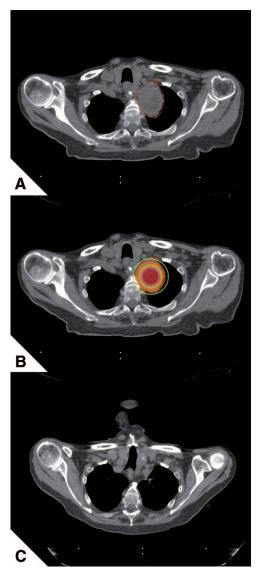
A 77-year-old man with squamous cell carcinoma of the left-sided superior sulcus. The patient suffered from chronic obstructive pulmonary disease, chronic renal insufficiency, and chronic cardiac insufficiency as coexisting morbidities and was medically not amenable to lung surgery. He rejected radiochemotherapy and was treated by sole interstitial high-dose-rate brachytherapy receiving four fractions of 8.0 Gy over 2 consecutive days to a total physical dose of 32.0 Gy. A, Axial computed tomography (CT)image obtained before the onset of treatment showing a massive lesion in the apical part of the left lung lobe. The single implanted catheter is marked with a red circle in the central part of the red delineated tumor volume (Target). B, Two-dimensional (2D)-isodose distribution after threedimensional (3D)-treatment planning for a plane lying centrally to the target extension. The color gradation represents the same isodose values as in Figure 1B. C, Axial CT image obtained at 13 months after brachytherapy showing no tumor regrowth.
